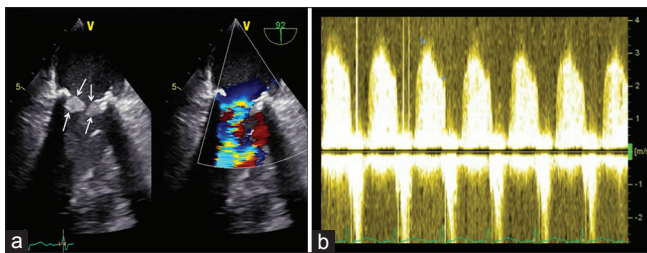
(a) Transesophageal echocardiography: two-dimensional showed thickened mitral valve leaflets (arrow) and color Doppler showed diastolic mitral inflow flow aliasing jet due to blood flow acceleration, and (b) Continuous wave Doppler of mitral valve inflow showed a significant increase in velocity
